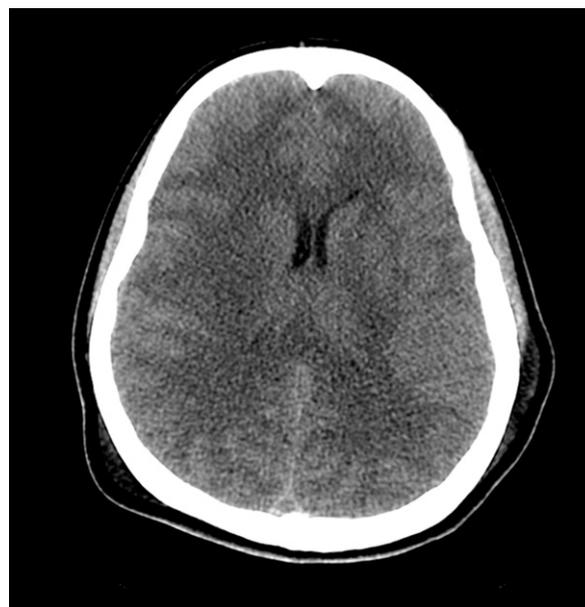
Computed tomographic scan showing effacement of the cerebral sulci consistent with cerebral edema.
